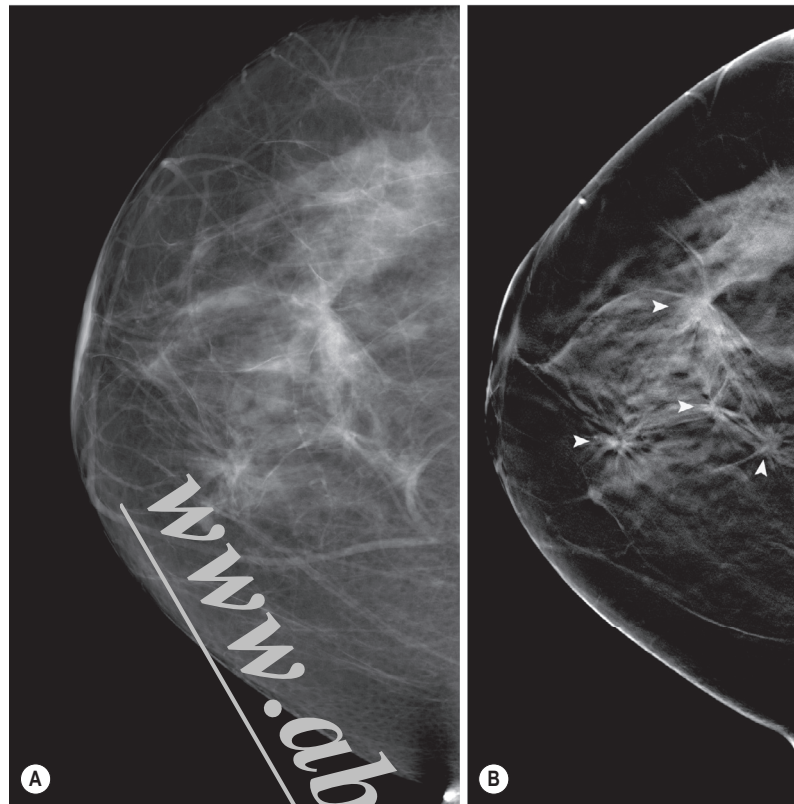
Digital Breast Tomosynthesis. This craniocaudal projection from a conventional 2D digital screening mammogram (A) shows several possible areas of distortion. This single slice from the digital breast tomosynthesis study (B) more clearly demonstrates four separate spiculate masses (*arrowheads*). A diagnosis of multifocal carcinoma was made following ultrasound guided biopsies and a mastectomy was performed.
